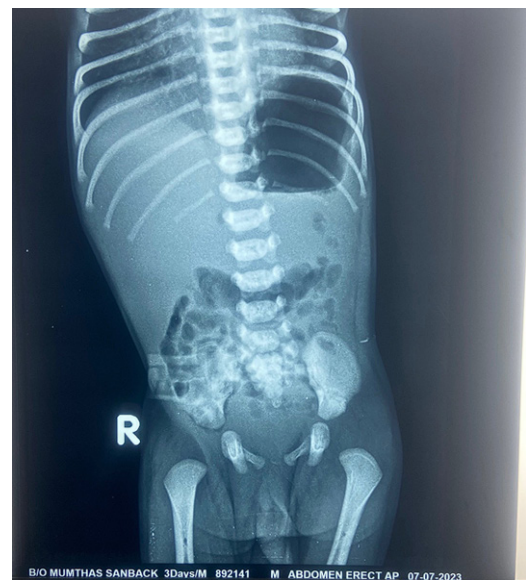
Plain x-ray abdomen : Dilated gastric shadow
